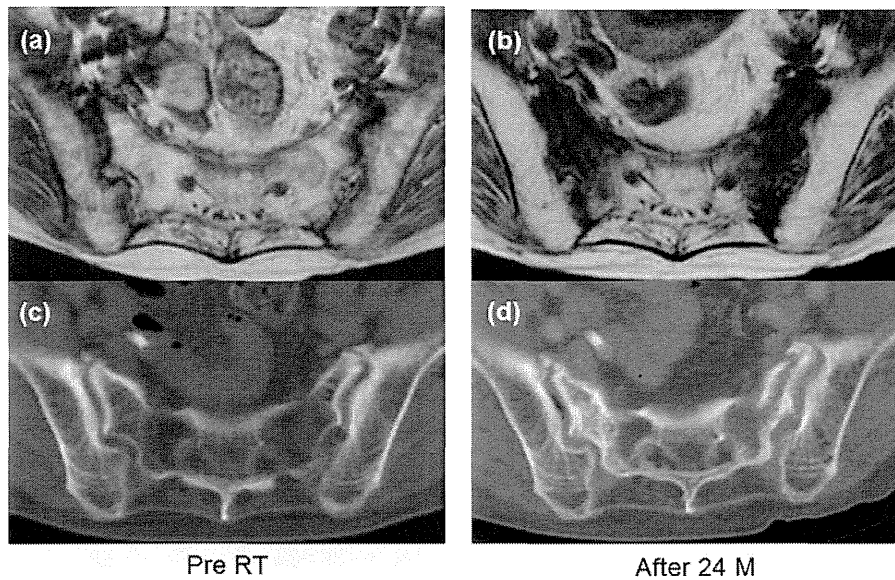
Pelvic MRI shows low signal intensity in both sacroiliac joints (b) after radiotherapy (RT). Pelvic bone window CT shows (d) cortical fractures and sclerotic changes in the bilateral sacroiliac joints. M = month.
